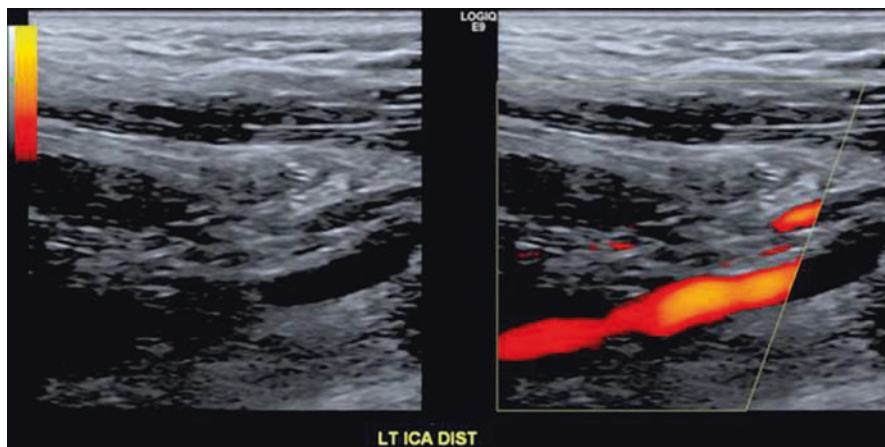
Fibromuscular dysplasia on ultrasound of a left internal carotid artery. Although more difficult to appreciate on carotid artery ultrasound, beading of the vessel can be identified on duplex ultrasound. Other common sonographic findings of fibromuscular dysplasia include turbulent flow and elevated velocities in the mid- and distal portions of the artery
